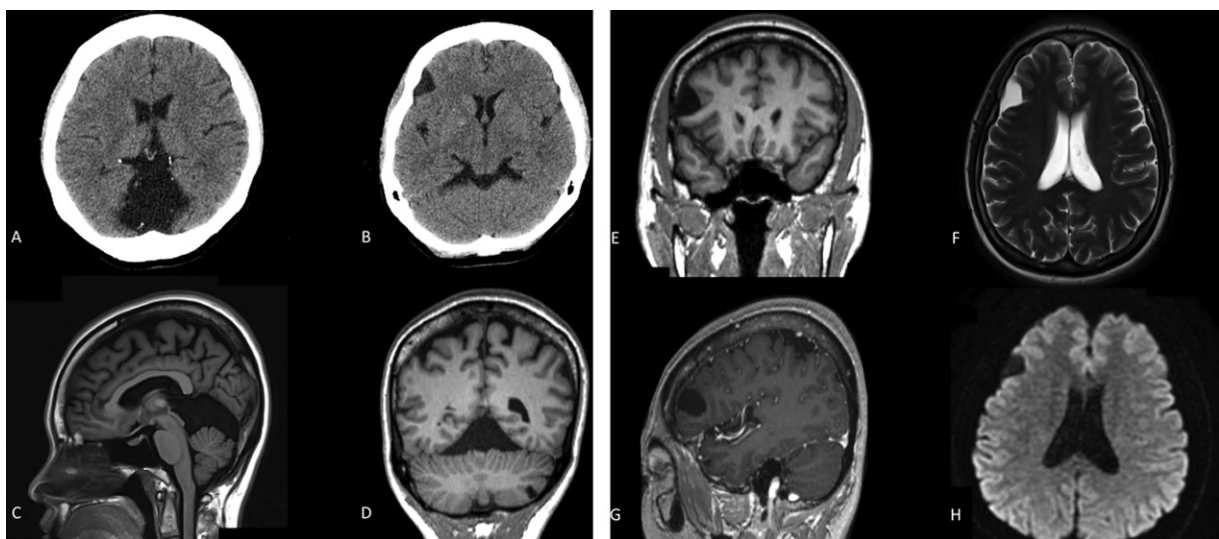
(A, B) Axial CT scans showing hypodense extra-axial lesions in the posterior fossa and right frontal lobe. (C, sagittal; D, E, coronal) MRI showing lesions that are hypointense on T1-weighted MRI, (F, axial) hyperintense on T2-weighted MRI, (G, coronal) non-enhancing on T1-weighted enhanced MRI and (H, axial) without significant restriction on diffusion-weighted imaging.
